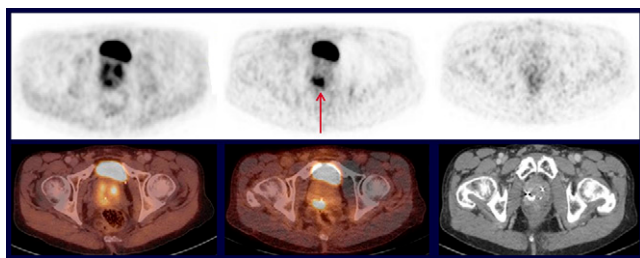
GRPR antagonist ^{68}Ga -RM2 PET and prostate cancer. PET (top row) and PET/CT (bottom row) in a 64-year-old man with primary prostate carcinoma and benign prostatic hyperplasia (BPH) and tumor positive biopsies with Gleason scores of 7a. The patient underwent external beam radiation therapy of the prostate with 54 Gy plus dose escalation to 74 Gy of the ^{68}Ga -RM2 PET-positive area. Left: ^{18}F -FECH images acquired at first examination before therapy did not distinguish between tumor and BPH; middle: ^{68}Ga -RM2 acquired at first examination before therapy shows focal tumor; right: ^{68}Ga -RM2 images acquired at second examination after irradiation, with no tumor visible.
